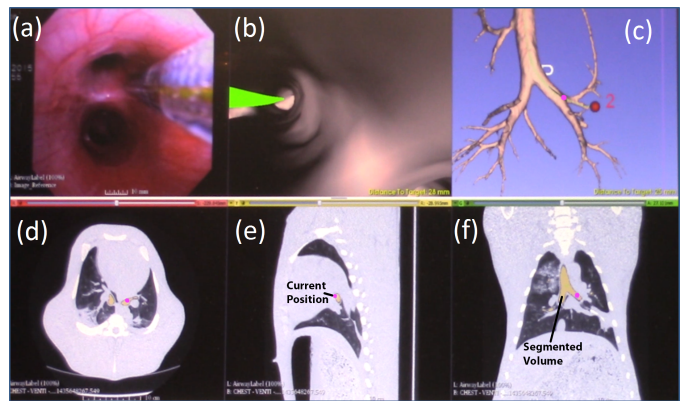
Screenshot of 3DSlicer mid-procedure. (a) View from bronchoscope camera feed showing the automated catheter within the airway. (b) Virtual camera view showing a first person perspective of the airway relative to the catheter tip. The green line shows the planned route towards the target fiducial. (c) Zoomed-out model of the lung model showing target fiducial marker. (d)-(f) Coronal, sagittal and axial views of the original CT scans. The catheter location is shown as a purple dot in views (c)-(f). The CT slices change dynamically to show the current position of the catheter. Yellow areas represent a portion of the segmented airway volume (c) in the context of the current slice.
